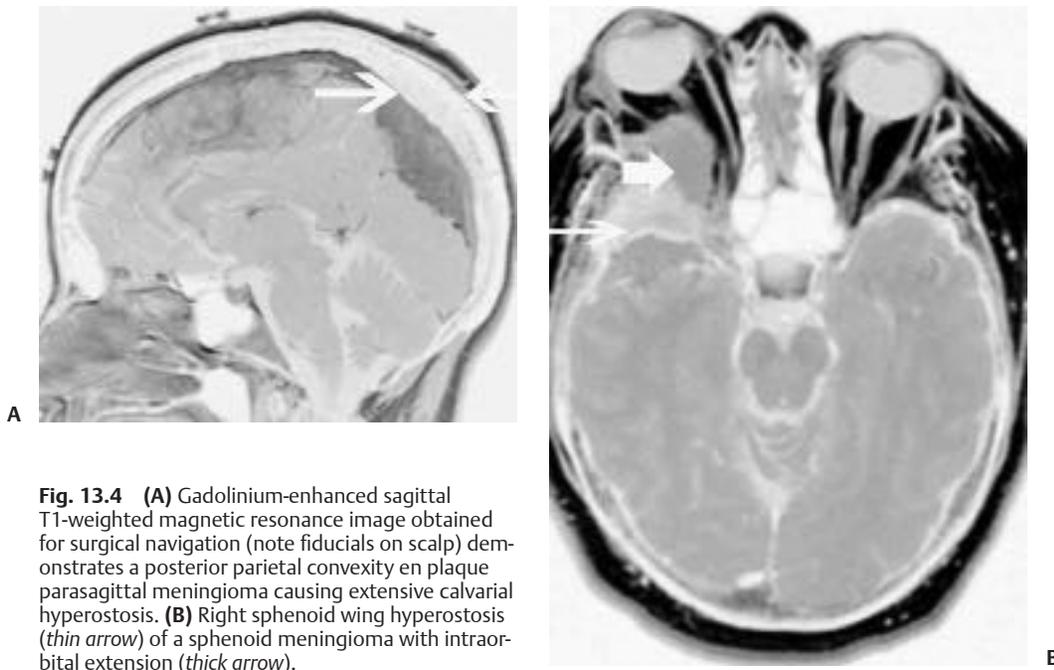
(A) Gadolinium-enhanced sagittal T1-weighted magnetic resonance image obtained for surgical navigation (note fiducials on scalp) demonstrates a posterior parietal convexity en plaque parasagittal meningioma causing extensive calvarial hyperostosis. (B) Right sphenoid wing hyperostosis (*thin arrow*) of a sphenoid meningioma with intra-orbital extension (*thick arrow*).
